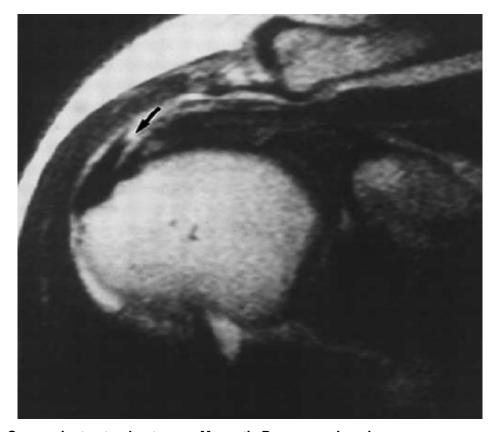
Supraspinatus tendon tear on Magnetic Resonance Imaging (From Matava et al. (2005). Partial-thickness rotator cuff tears. *American Journal of Sports Medicine*, 33, 1405-1417).
